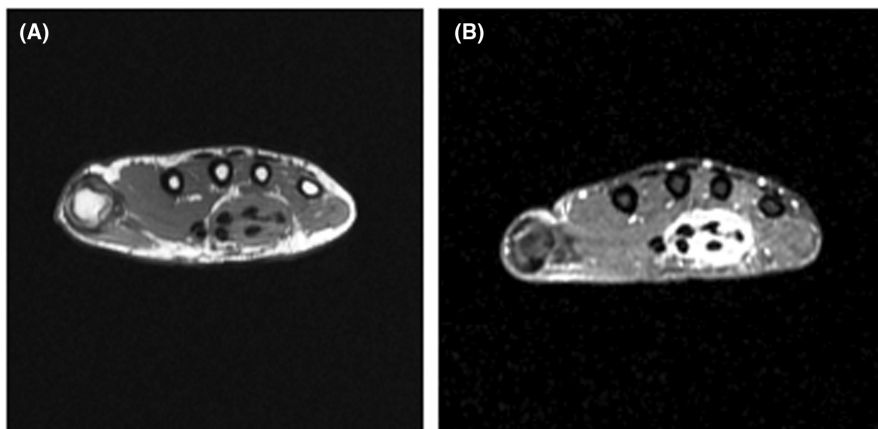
(A) T1 weighted MRI image of the left hand showing thickening of flexor sheaths. (B) Post-gadolinium sequence demonstrating avid enhancement of the thickening of flexor sheaths
